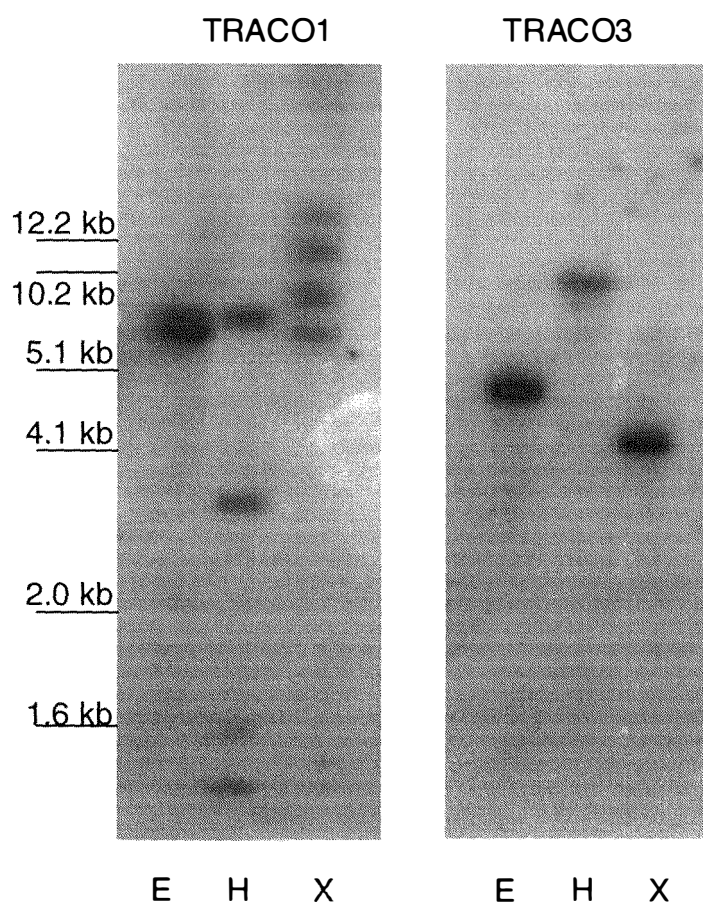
Southern analysis with genomic DNA using 3'-UTRs as probes. Ten μg of the genomic DNA was digested with EcoRI (E), HindIII (H), and XbaI (X) overnight, separated on a 0.8% (w/v) agarose gel and blotted onto N⁺-Hybond membrane with alkaline transfer buffer. Each membrane was hybridized with ³²P-labeled TRACO1 and TRACO3 (as indicated), and exposed to X-ray film for 7 days. Molecular sizes are indicated.
